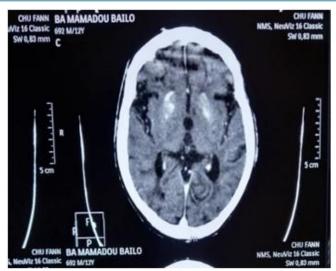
Brain CT axial slice, parenchymal window above tensor level
